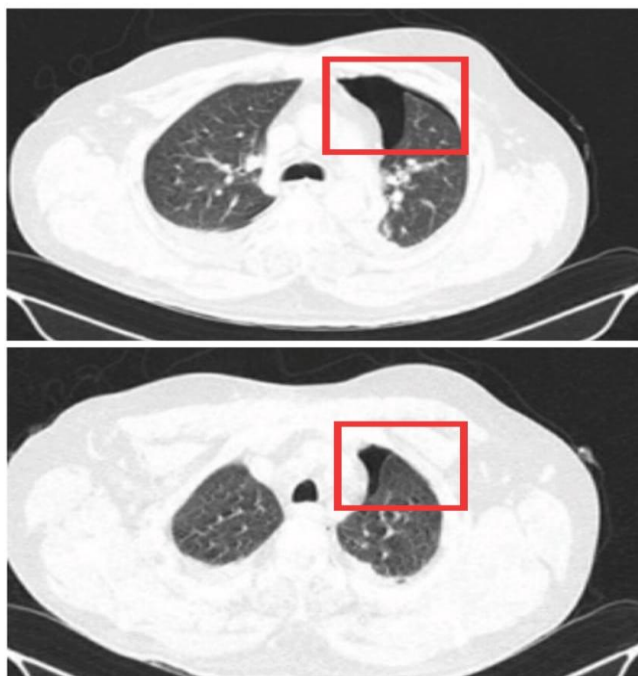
Shows HRCT thorax findings which revealed left sided pneumothroax causing passive atelectasis of left upper lobe.
